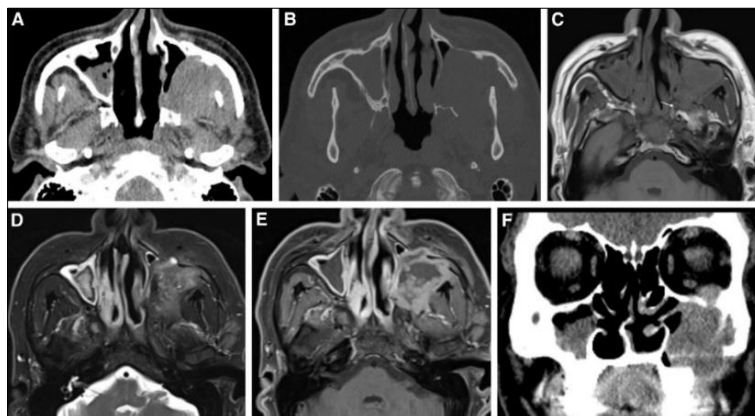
CT images of chronic invasive fungal rhinosinusitis. (A) Soft tissue window and (B) bone window noncontrast computed tomography (CT) images show a mass in the left maxillary sinus with lateral wall erosion. (C) Axial T1-weighted MRI image without contrast shows extension into the pterygopalatine fossa (arrow). (D) T1 postgadolinium fat-saturated MRI shows a low-signal mass. (E) T1 postgadolinium fat-saturated MRI shows peripheral enhancement of the mass, with a nonenhancing central component. Resection shows chronic granulomatous invasive fungal rhinosinusitis with dense fibrous tissue, focal necrosis, and chronic inflammatory infiltrate. (F) Coronal non-contrast CT image shows erosion of the left inferior orbital wall with soft tissue extension into the orbit⁵
